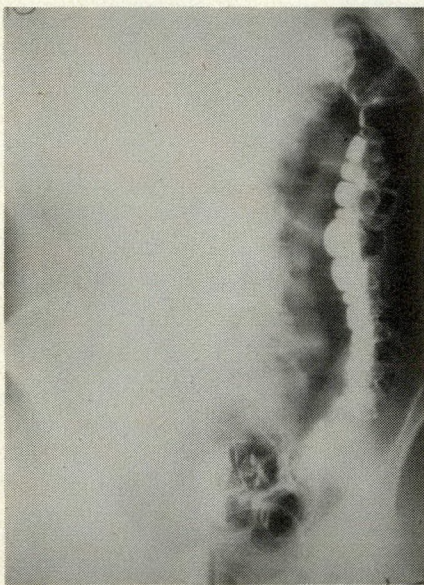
Case 2. Roentgenogram after barium enema shows malrotation of intestine and long-standing ulcerative colitis.
